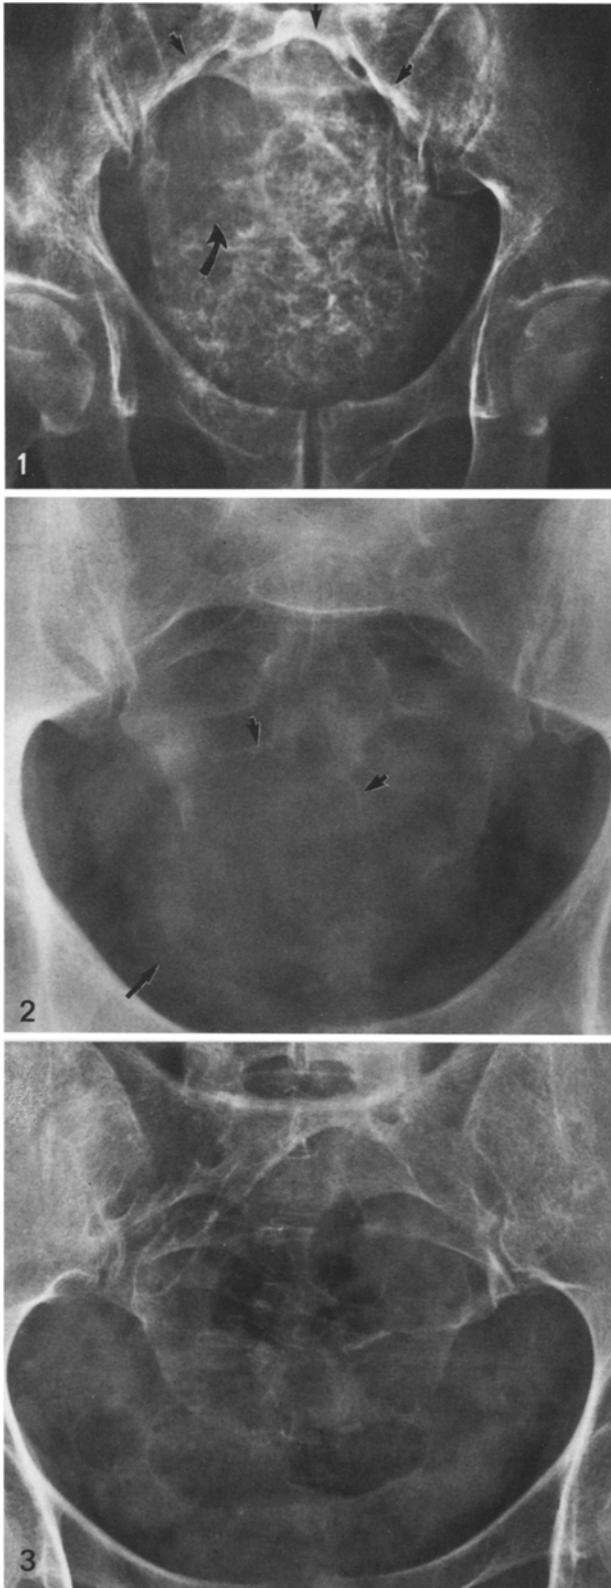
Plain film. Massive tumor involving most of the sacrum which is expanded with a dense superior cortical rim (arrows). Extensive calcific debris was present throughout the tumor with a bare area in upper sacrum, where obvious destruction is seen.
